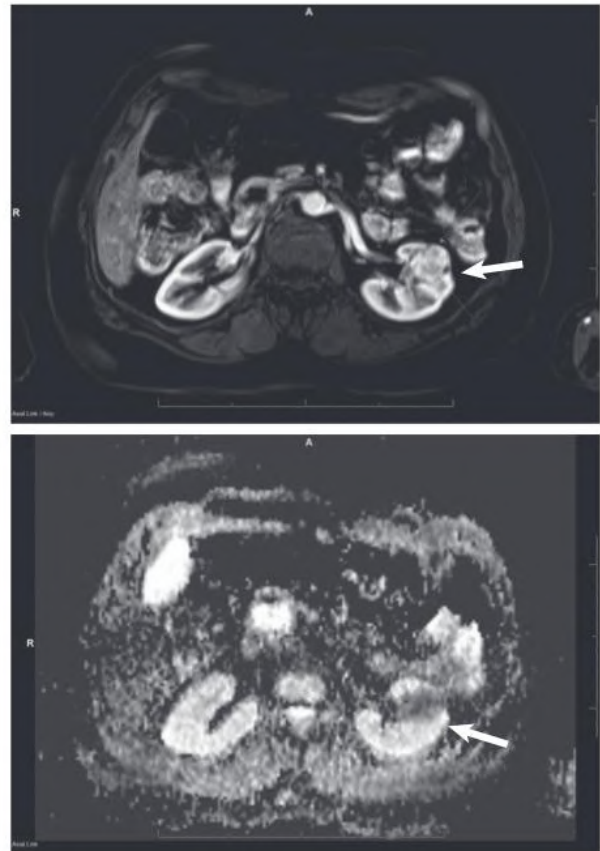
Magnetic Resonance Image of Kidney Tumor. T1-weighted, contrast-enhanced image shows enhancing left renal tumor.
